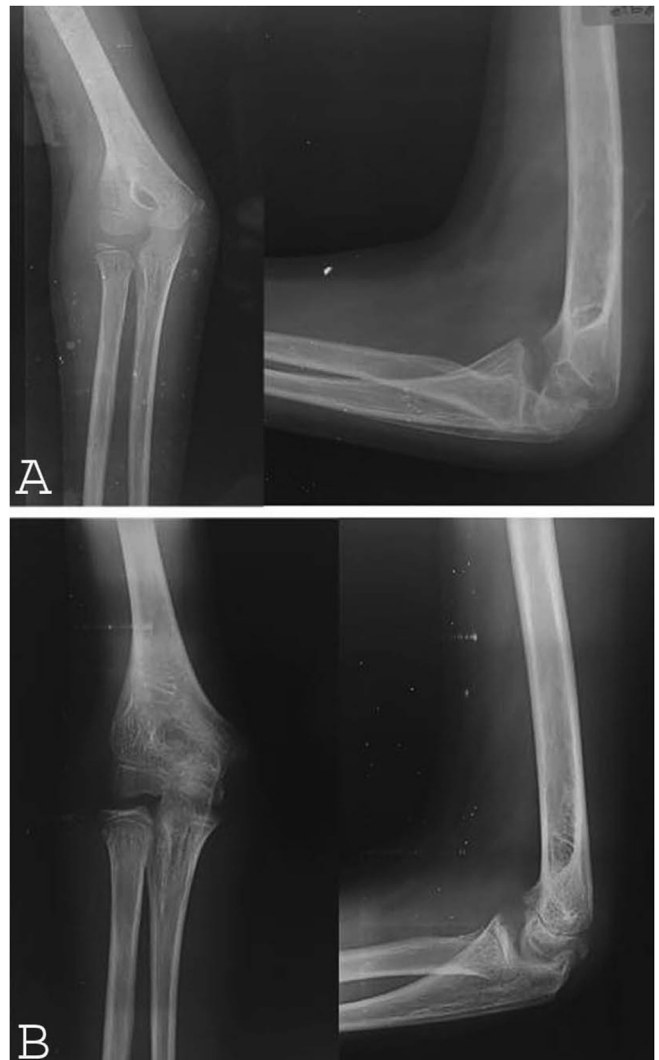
An eight-year-old female child with pain, swelling and restriction of her left elbow movements of 4 months duration. At diagnosis: osteopenia, 'ice cream' scoop sign, partial resorption of radial head on elbow AP and lateral Radiographs (A,B) is noted. At follow up of 1-year post ATT, 'ice-cream' scoop sign has partially recovered. There is re-ossification of radial head, irregularity of joint but still with good function.
